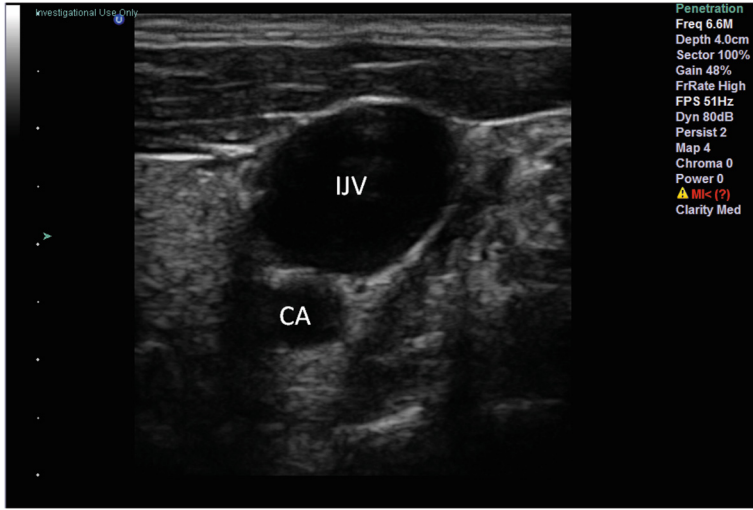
Ultrasound images of a healthy volunteer. The image has been labeled with the carotid artery (CA) and internal jugular vein (IJV) for reference.
